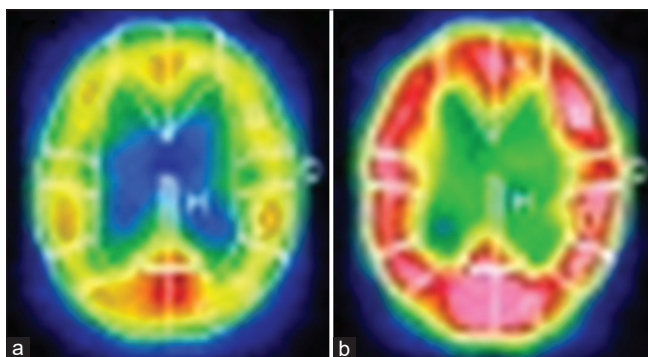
99 m-Tc single-photon emission computed tomography (SPECT) images at the age of 41 show no differences in cerebral blood flow (CBF) at rest (a) and no hemodynamic compromise after acetazolamide challenge (b).
